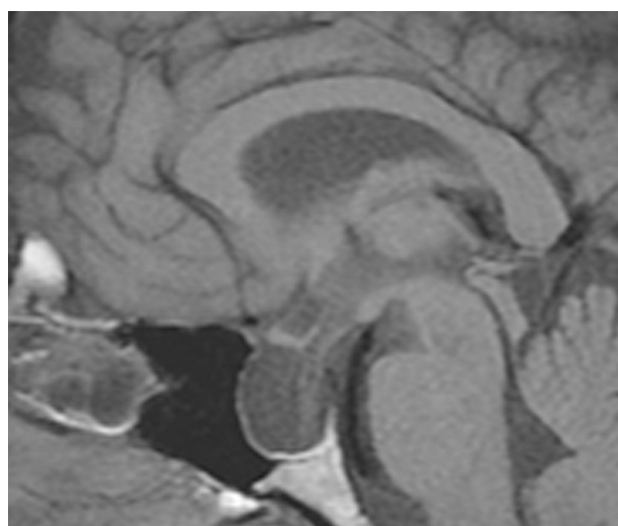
Non-contrast sagittal T1 MRI of an empty sella with no pituitary tissue [15]
